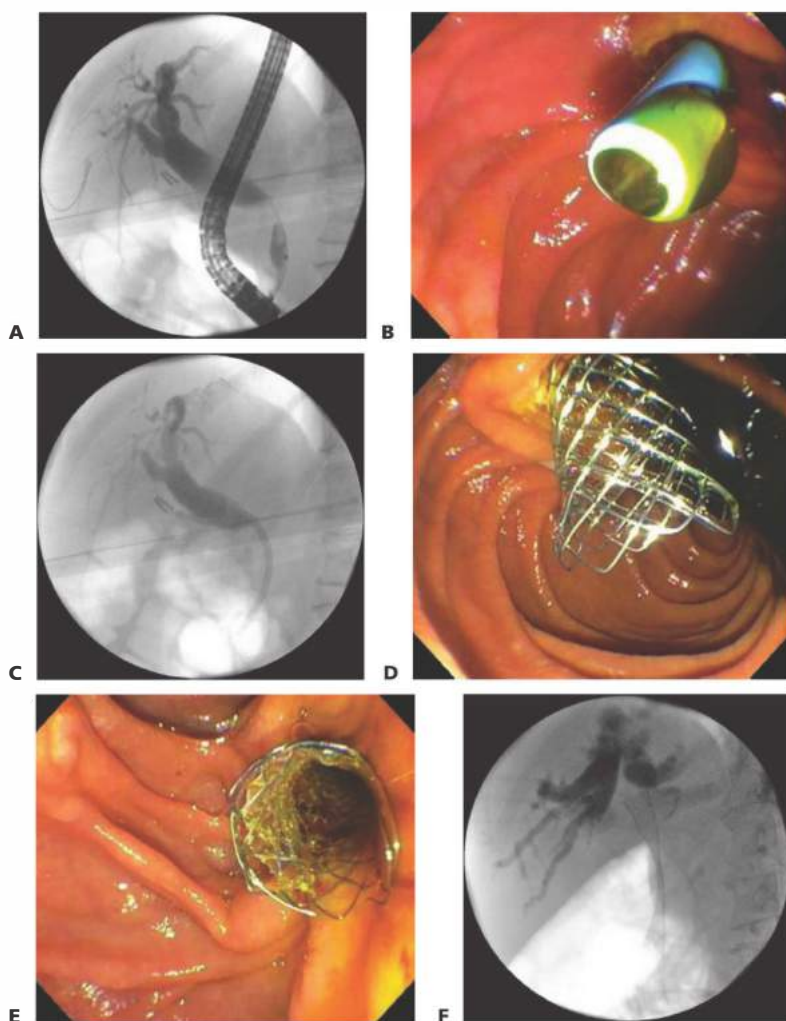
• Endoscopic and fluoroscopic views of plastic and metal biliary stents. A. Fluoroscopic view of a biliary stricture. B. Endoscopic image of a deployed plastic biliary stent. C. Radiographic appearance of a plastic biliary stent. D,E. Endoscopic views of a well-positioned metal biliary stent. F. Fluoroscopic appearance of a metal biliary stent.
